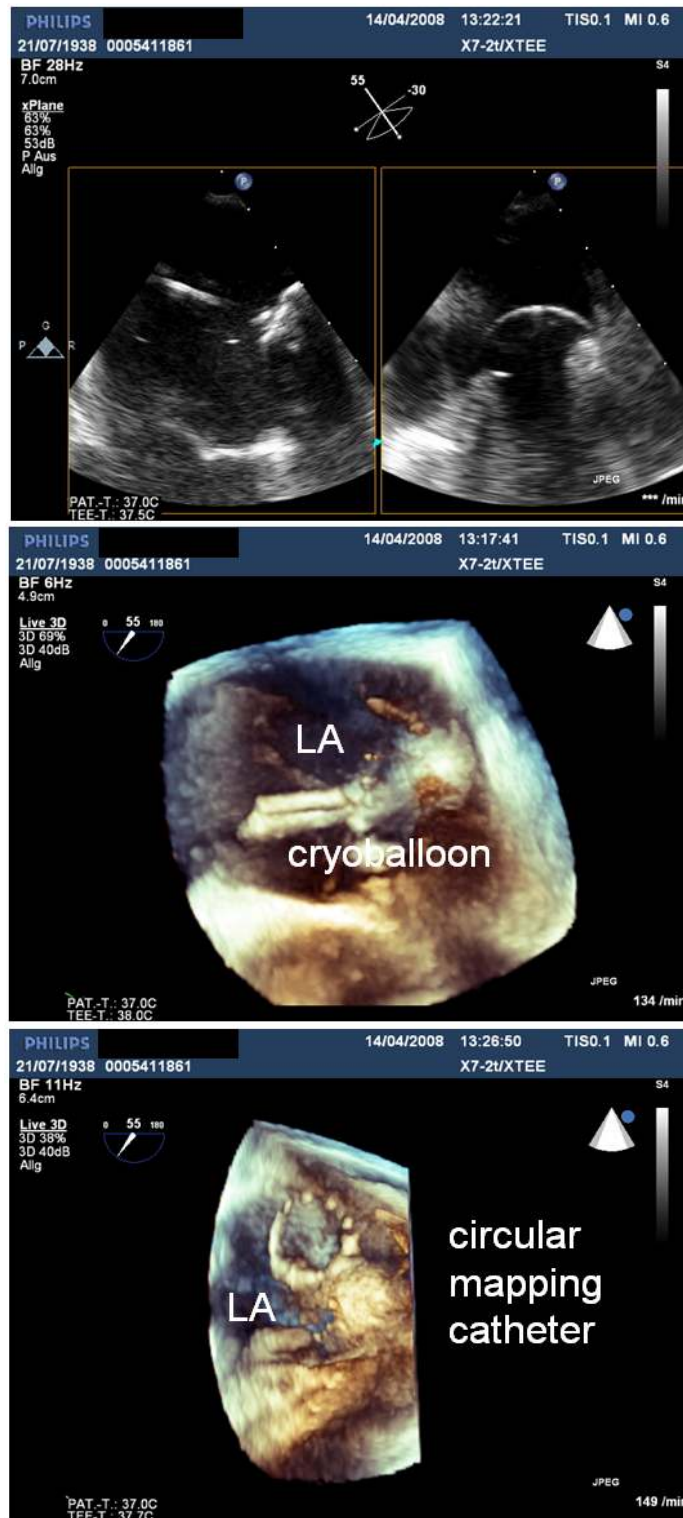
Cryoablation of atrial fibrillation: Visualization of the cryoballoon (Arctic Front; Medtronic) and the circular mapping catheter (Lasso 2515; Biosense Webster) during the ablation procedure by three-dimensional transesophageal echocardiography
